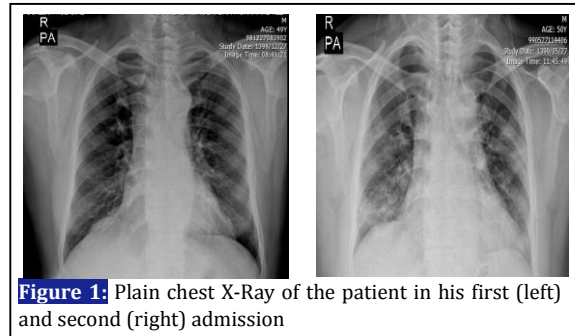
Plain chest X-Ray of the patient in his first (left) and second (right) admission
